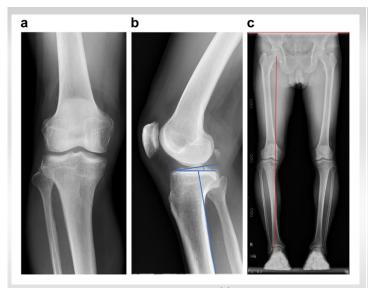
Plain radiography of the knee. (a) Plain radiography frontal view of the right knee showing no osteoarthritis. (b) Plain radiography lateral views of the right knee showing a posterior tibial slope (blue arc) of 11°. (c) Plain radiography of the lower limbs with weight-bearing showing the mechanical axis percentage of the right limb (red line) was 17%, indicating a varus mechanical axis.
